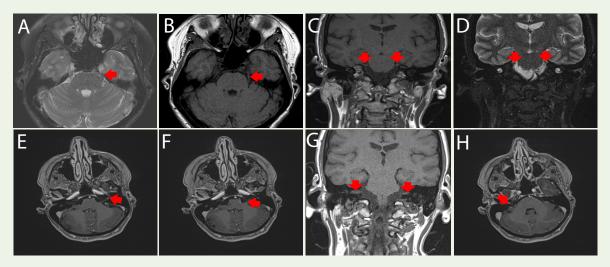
(A&B) Axial T2 fat sat thin sequence of MRI brain with and without contrast showing bilateral trigeminal nerve cisternal segment enhancement with associated T2 hyperintensity as shown with the red arrows. (B) Axial T1 sequence of MRI brain with and without contrast showing bilateral trigeminal nerve cisternal segment as shown with the red arrows. (C) coronal T1 sequences of MRI brain with and without contrast showing bilateral trigeminal nerve cisternal segment as shown with the red arrows. (E&F) Axial T2 fat sat thin sequences of MRI brain with and without contrast showing bilateral facial nerve canalicular segment enhancement as shown with the red arrows. (G) Coronal T1 sequence of MRI brain with and without contrast showing bilateral facial nerve canalicular segment enhancement as shown with the red arrows. (H) Axial T2 fat sat thin sequence showing cochlear nerve enhancement as shown with the red arrows.
